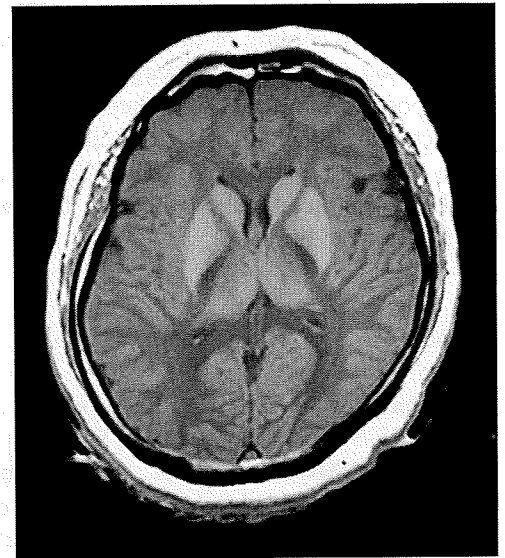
A 37-year-old woman. Postmortem magnetic resonance imaging (MRI): T1-weighted image (T1WI) of the brain performed 36 h after confirmation of death shows high signal intensity of the basal ganglia and thalamus compared to surrounding white matter
